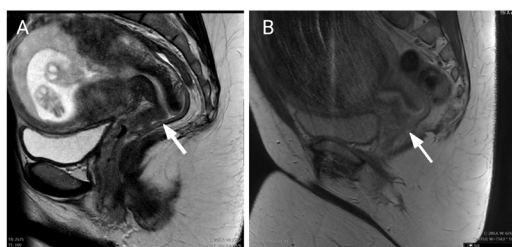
Sagittal T2-weighted image of the pelvis at 14 weeks of gestation at diagnosis (A), at 27 weeks of gestation after three cycles of carboplatin-paclitaxel (B). at 27 weeks of gestation, there was a limited decrease in tumor size, but a clear decrease in diffusion restriction, indicative of a good radiological response. However, at 31 weeks of gestation, we noted a stagnation of the oncological response. Arrow to cervical tumor.
